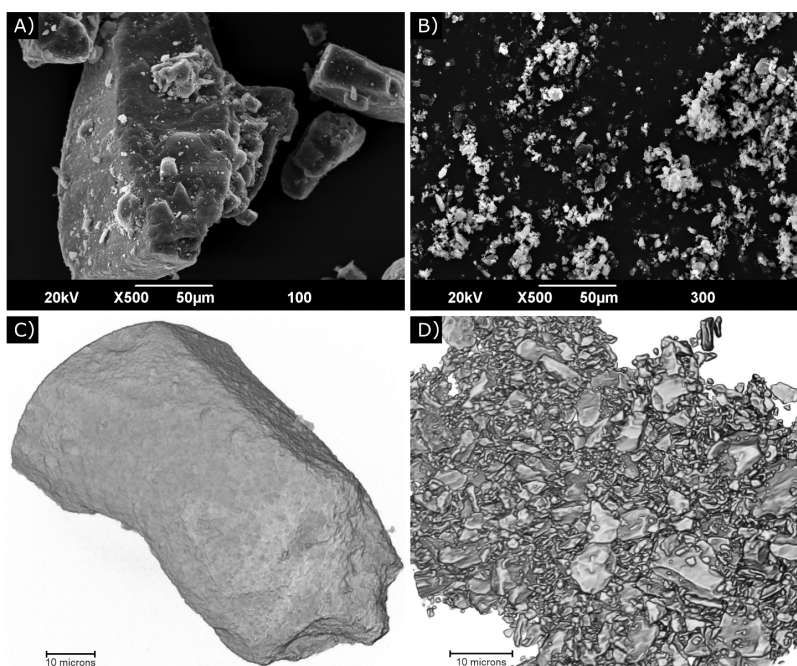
SEM images showing the particle morphology of A) Lactohale 100 and B) Lactohale 300. 3D visualizations of nano-CT scans of C) a single Lactohale 100 particle, and D) a single Lactohale 300 agglomerate.
